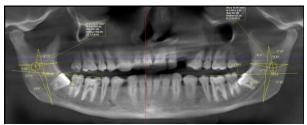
The shortest distance from the MF to numerous mandibular landmarks on panoramic view of CBCT.
